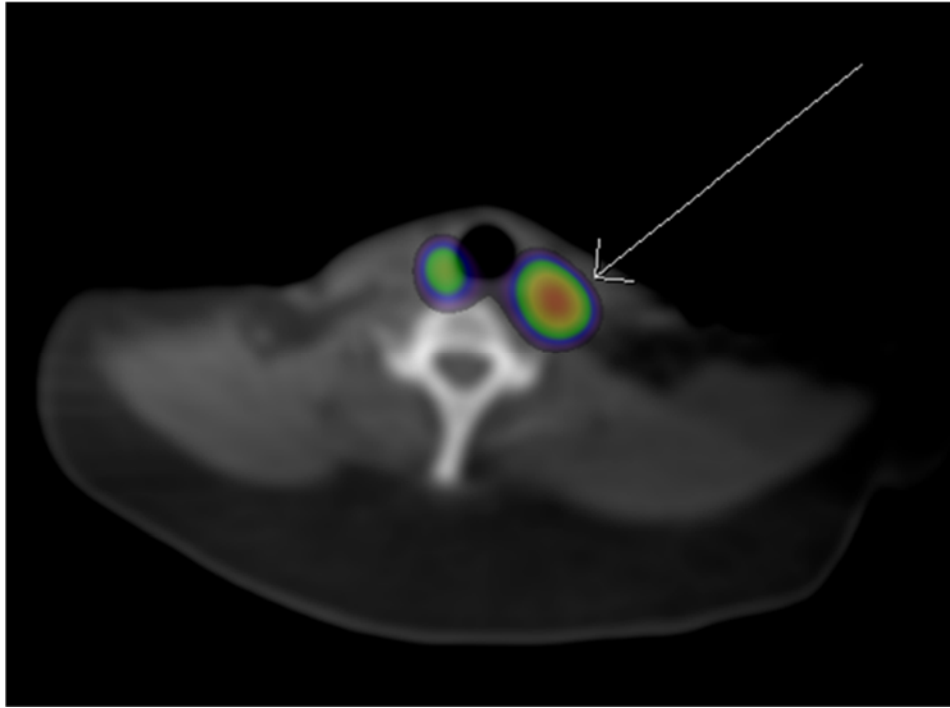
SPECT/CT data localizes uptake posterior and lateral to the superior left thyroid gland.
